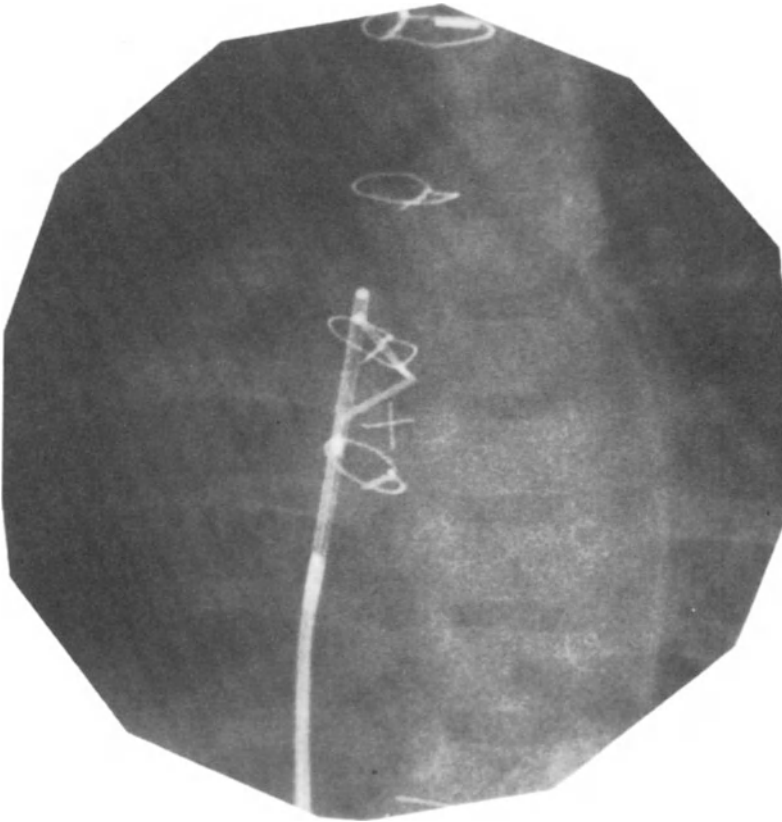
PA and lateral roentgenogram of a septostomy blade opened in the left atrium of a patient with mitral atresia. Prior to pulling across the atrial septum, the blade is positioned leftward and about 30° anterior
